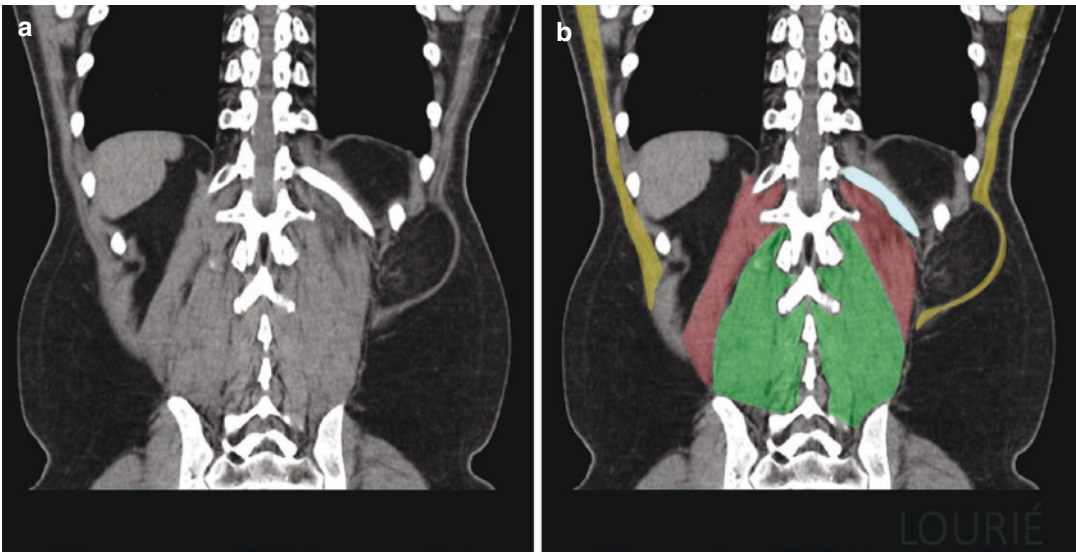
Left-sided Grynfeltt-Lesshaft hernia. (a) Coronal CT abdomen cut, same patient as (Fig. 20.2) (b) Same image, colored. Note the hernia defect occurs inferior to the tip of the 12th rib (*light blue*). Note the pathologic convexity of the left latissimus dorsi muscle (*yellow*)
